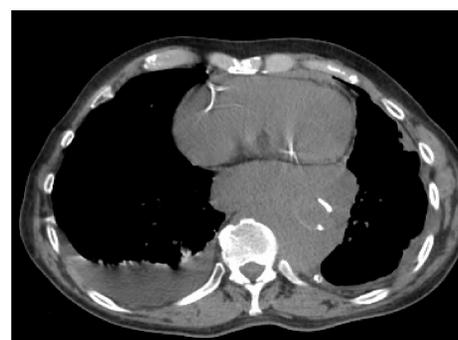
Repeat non-contrast CT at our institution. Mass larger in size compared to Figure 1. Small pleural effusion now present on the right side. Descending aorta moderately calcified
